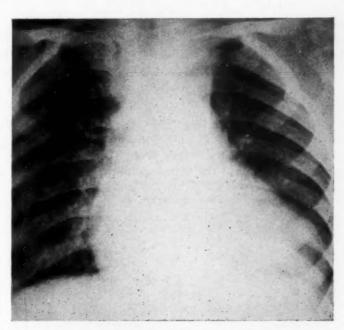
Case 7. A 6-foot posteroanterior chest radiograph. There is considerable cardiac enlargement and a wide superior mediastinal shadow. The left middle third of the cardiac contour is straight but neither the main pulmonary artery nor its right and left branches can be seen. Pulmonary vascular markings are more conspicuous on the right than on the left.
